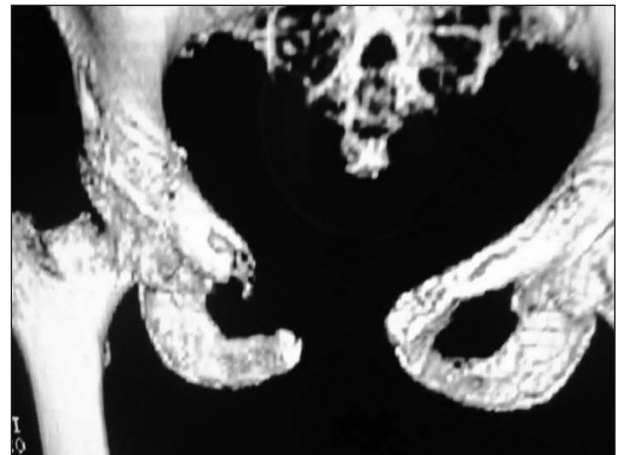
Computed tomography of pelvis with 3 D reconstruction suggestive of osteomyelitis of right pubic bone
